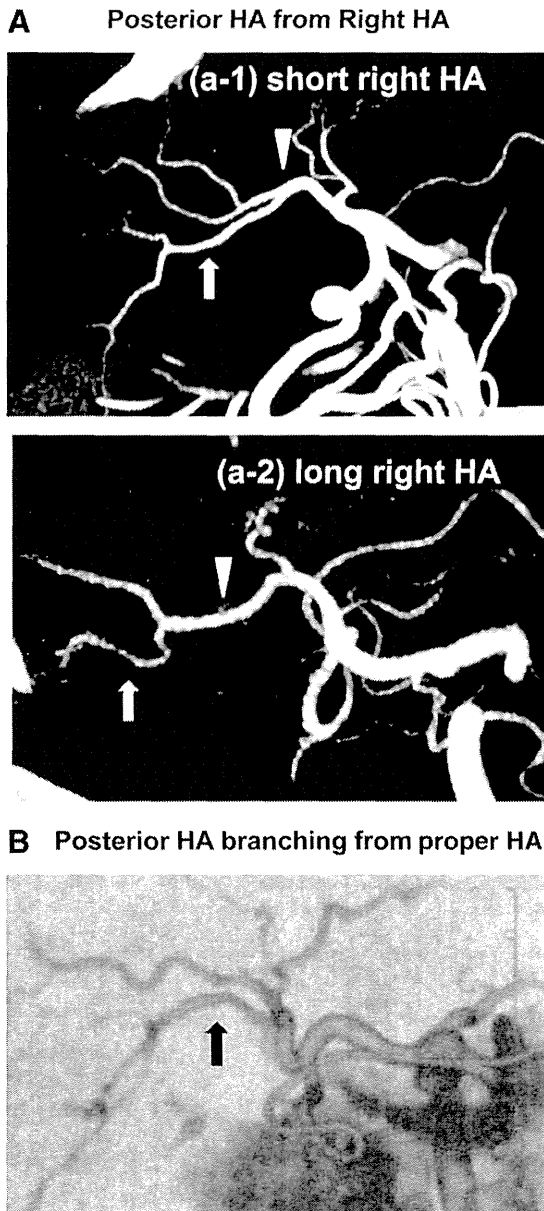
Anatomical HA variations according to preoperative 3-dimensional CT. (A) The right PHA and the right anterior HA were branching from the right HA (arrowhead; cases 2-8). The length of the extrahepatic PHA (arrow) was dependent on the length of the right HA. (a1) The liver had a long extrahepatic PHA (cases 2 and 6). (a2) The liver had a short extrahepatic PHA due to a long right HA (cases 3-5, 7, and 8). (B) The right PHA was branching from the proper HA (case 1). The extrahepatic PHA (arrow) was relatively long in this variation.
